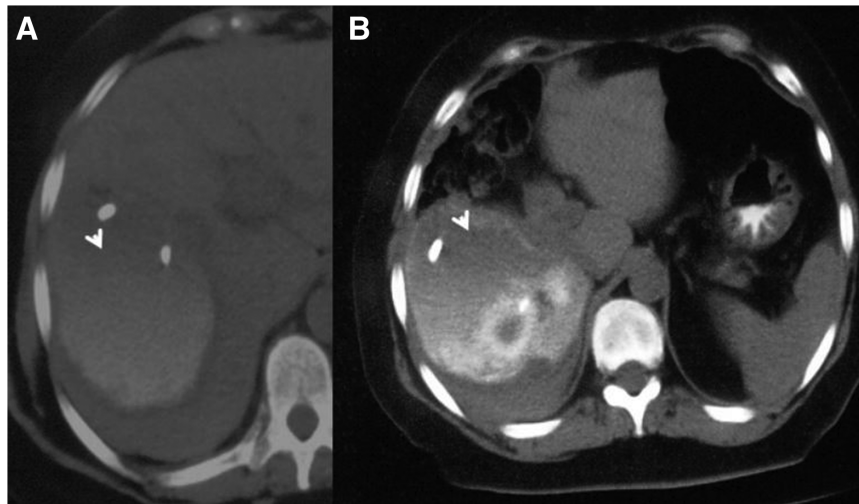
Multidetector CT scan without contrast medium during emergency setting (A and B) for hemoperitoneum post-radiofrequency ablation treatment. The bleeding is hyperdense (arrow).
